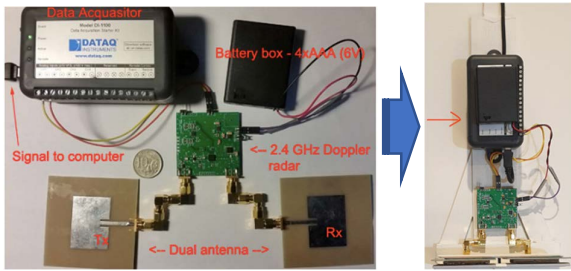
Doppler sensor components are mounted on a wooden stick, making it easier to maneuver and create random variation datasets rather than placing the sensor on the actual surface.
